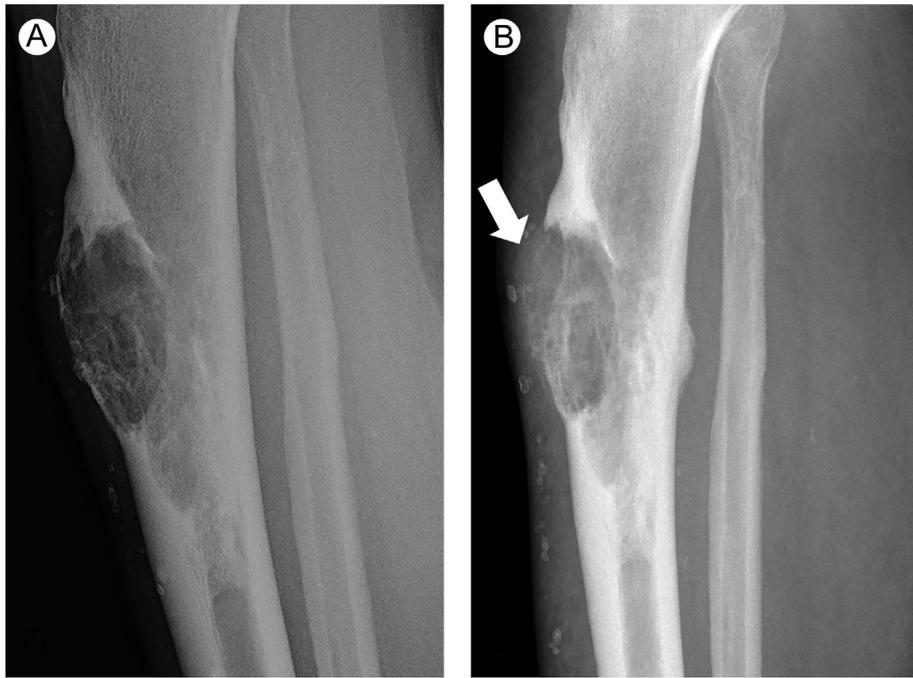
Lateral radiograph of the left tibia demonstrates a lytic lesion centered in the proximal tibial diaphysis. A, The lesion demonstrates cortical expansion and peripheral areas of sclerosis. B, A 3-month follow-up lateral tibial radiograph demonstrates progression of anterior cortical destruction, arrow.
